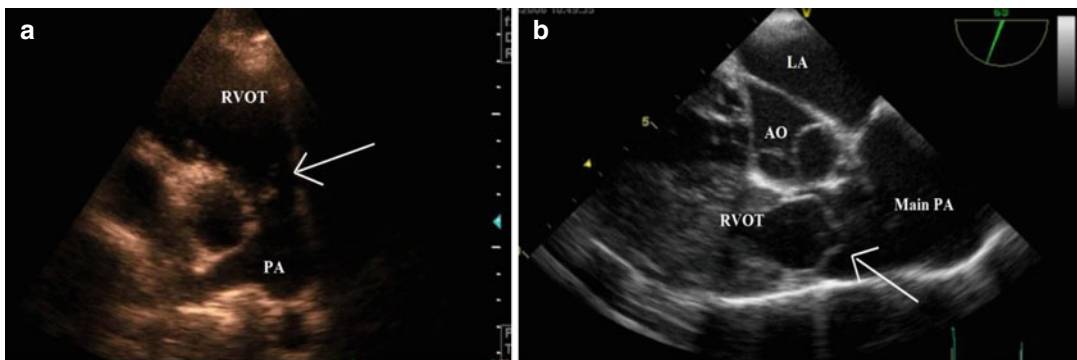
(a, b) 2D echocardiography imaging of dome-shaped and stenotic pulmonary valve in both transthoracic and transesophageal echocardiography. *RVOT* right ventricular outflow tract, *PA* pulmonary artery, *LA* left atrium, *AO* aorta
